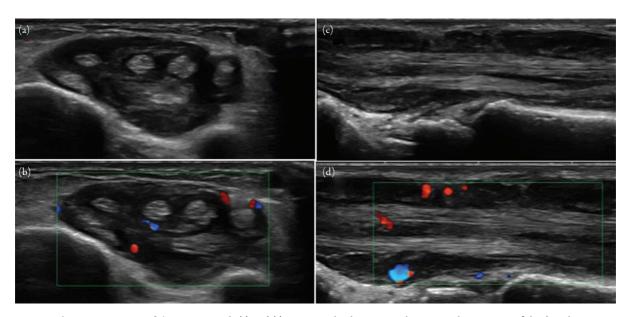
Complex tenosynovitis of the wrist. Panels (a) and (c), respectively, show grayscale sonographic imaging of the dorsal wrist in transverse and longitudinal planes with a complex tenosynovitis involving the fourth dorsal extensor compartment tendon sheath. The tendon sheath is expanded with solid-appearing echogenic material that has increased flow on color Doppler (Panels (b) and (d), respectively). The findings suggest synovitis with active inflammation.
